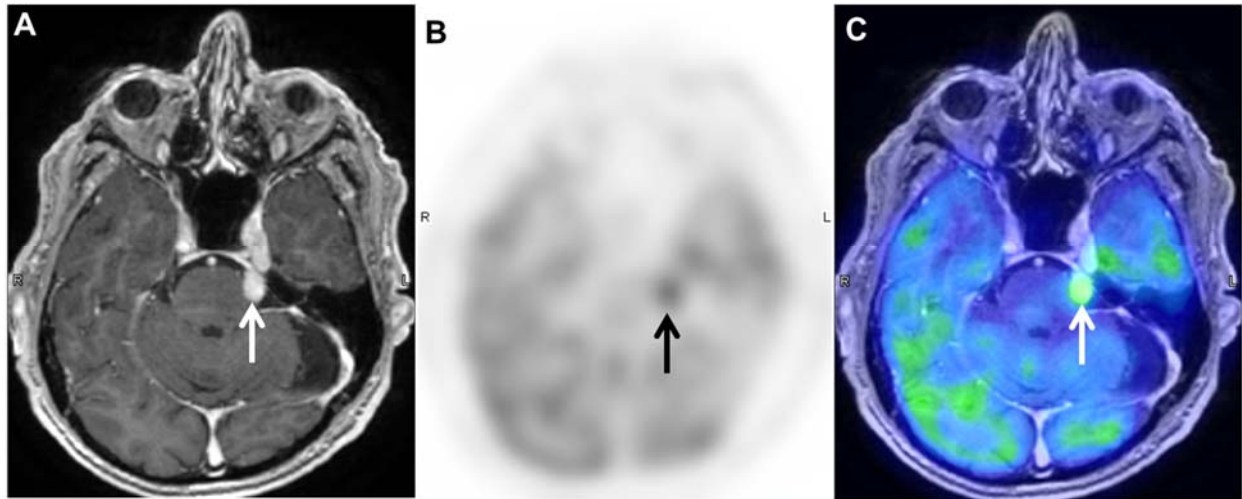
Contrast enhanced brain MRI showed enhancing lesion involving left trigeminal nerve (arrow in A), which was 18F-FDG avid with SUVmax 6.3 on restaging 18F-FDG PET image (arrow in B) and fused MR/PET image (arrow in C).
